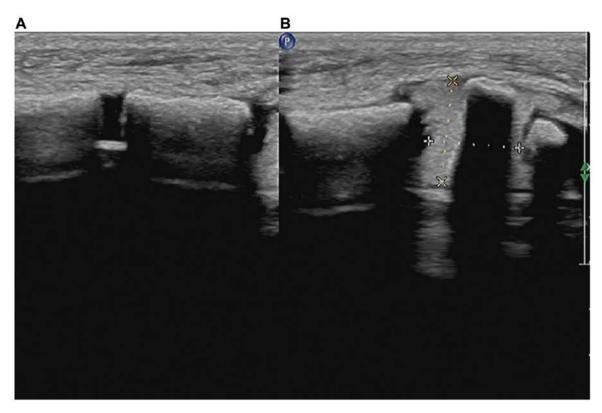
Sternal Doppler US findings in case A. (A) Normal ultrasound image of the superior sternal segment. (B) The position of the lower sternal section was abnormal and the peripheral periosteum displayed with echo enhancement, and the crosshairs indicated the length and width of the sternal lesion.
